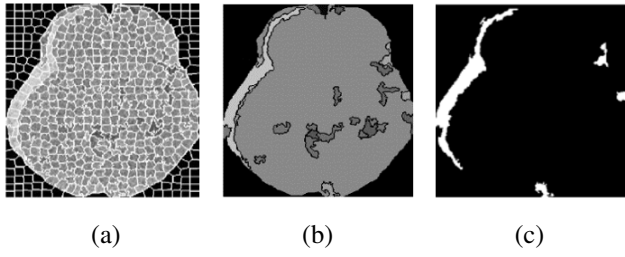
CT image: a) The superpixels, b) RAG grayscale output, c) Result of SLIC Algorithm.
